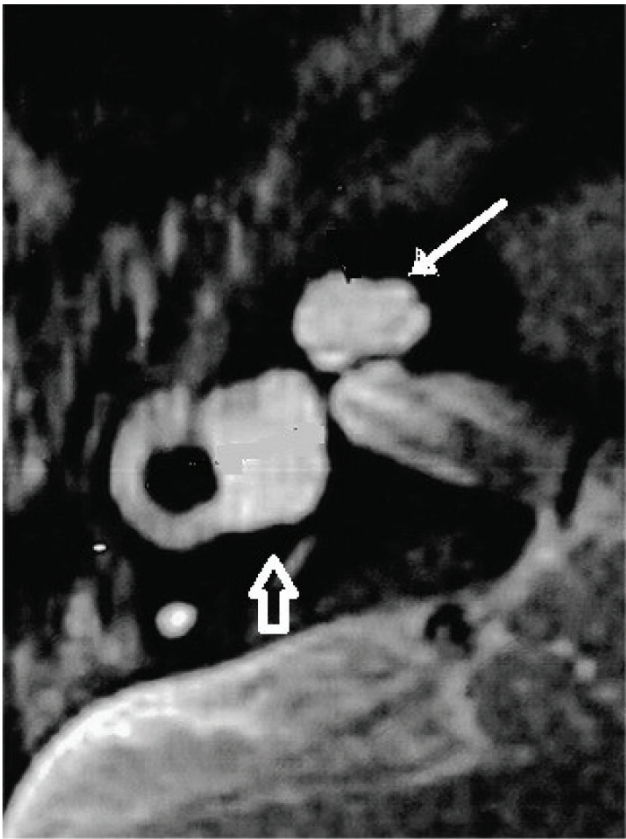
Detail of axial T2-weighted MRI scan of the right ear of patient #14, showing cystic cochlear apex (thin arrow) and enlarged vestibule (empty arrow).
